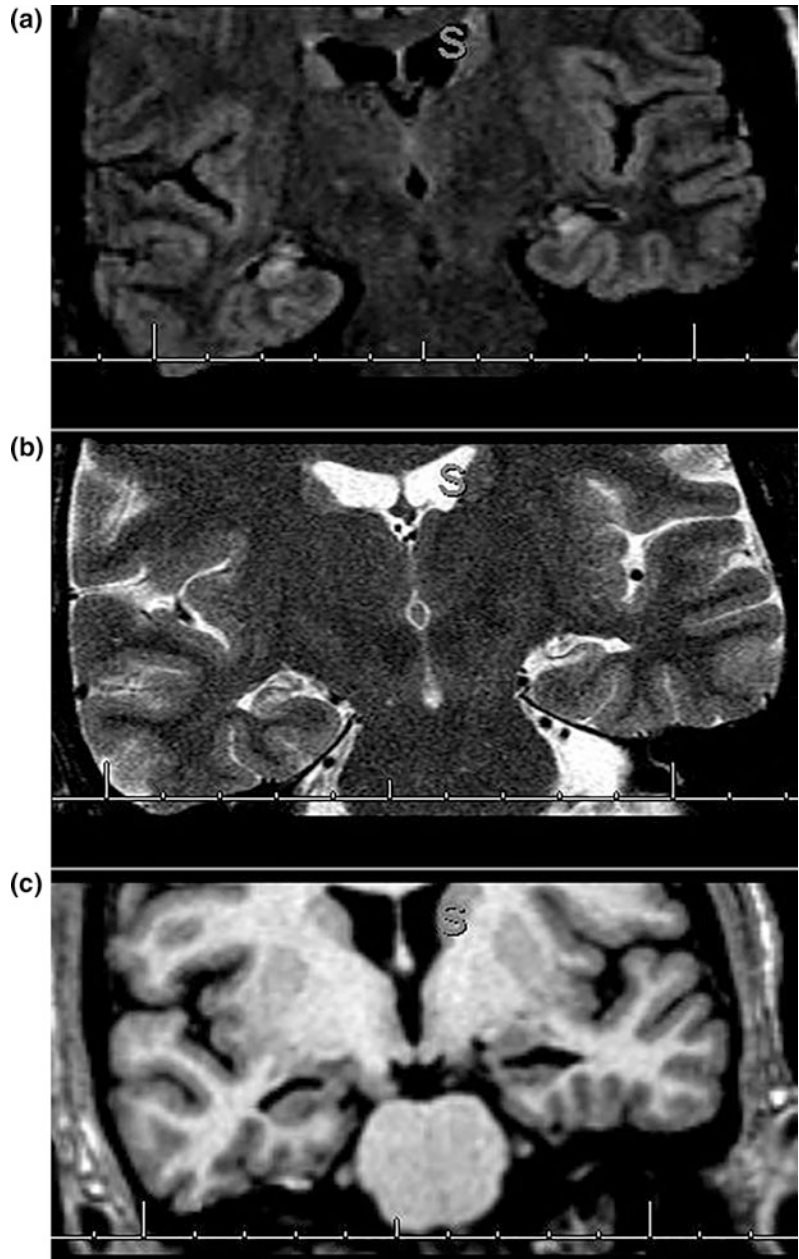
Coronal T2-weighted images demonstrating globular left hippocampus (*arrow*, panel a) more vertical left collateral sulcus and low-lying left body of the fornix (*arrow*, panel b) consistent with incomplete hippocampal
